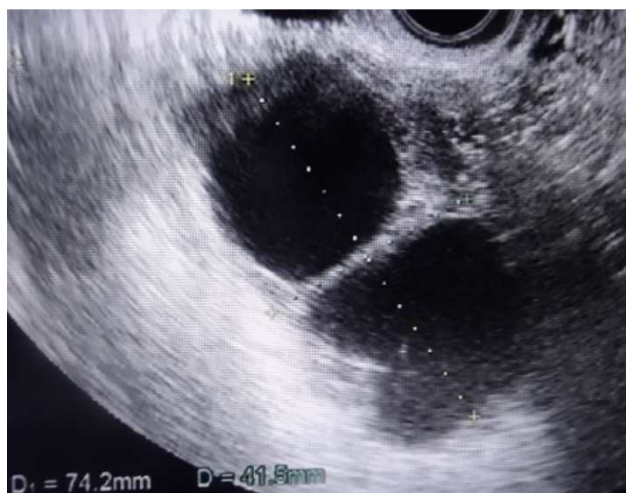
Transvaginal ultrasound images showing reduction in the size of the polycystic ovaries. The right ovary measured 74.2mm × 41.5mm.
